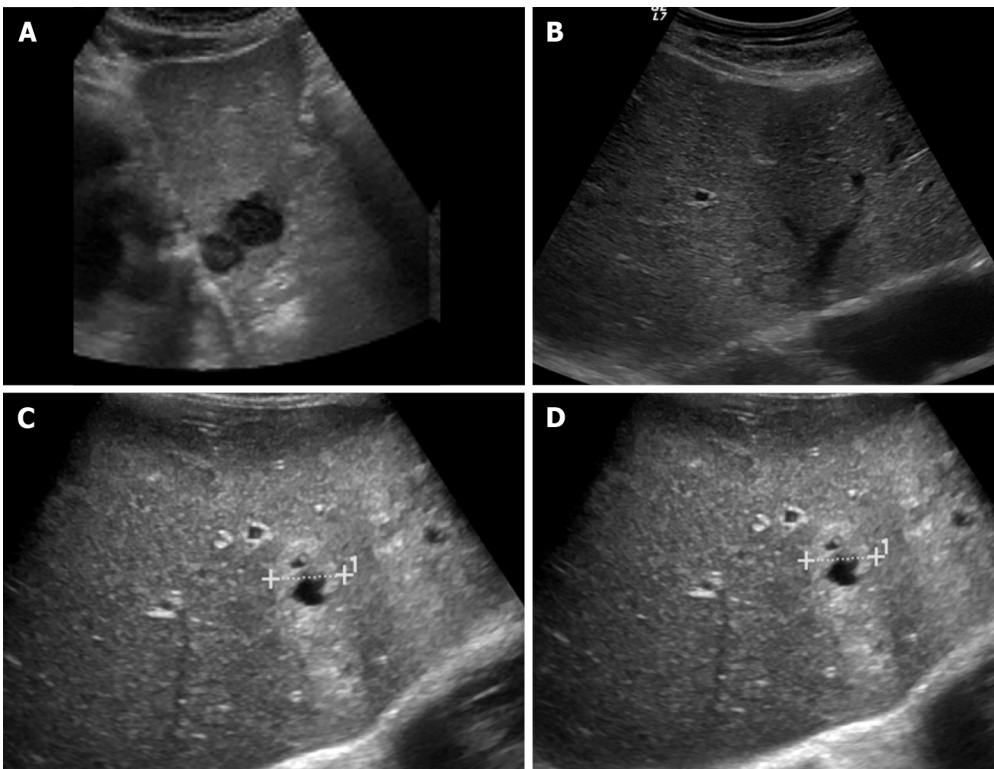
Ultrasound images showing variable echogenicity of liver metastases. A: Two hypoechoic lesions in the left liver lobe consistent with metastases in a patient with lung cancer; B: Isoechoic liver metastasis from lung cancer demonstrating a hypoechoic halo; C: Occult primary tumor with hepatic metastases, predominantly solid and hyperechoic; D: Occult primary tumor with hepatic metastases, showing central necrosis.
